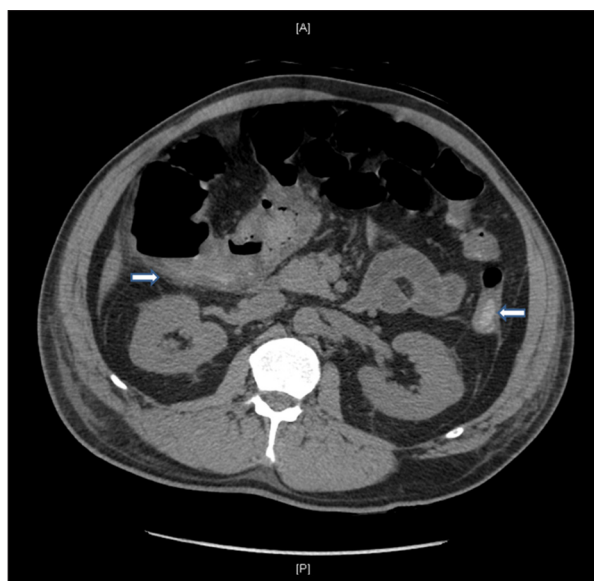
CT abdomen. Thickening and paracolic fat stranding of proximal colon, hyperdensity in right hepatic flexure lumen consistent with blood (right arrow). Descending colonic wall thickening (left arrow).
